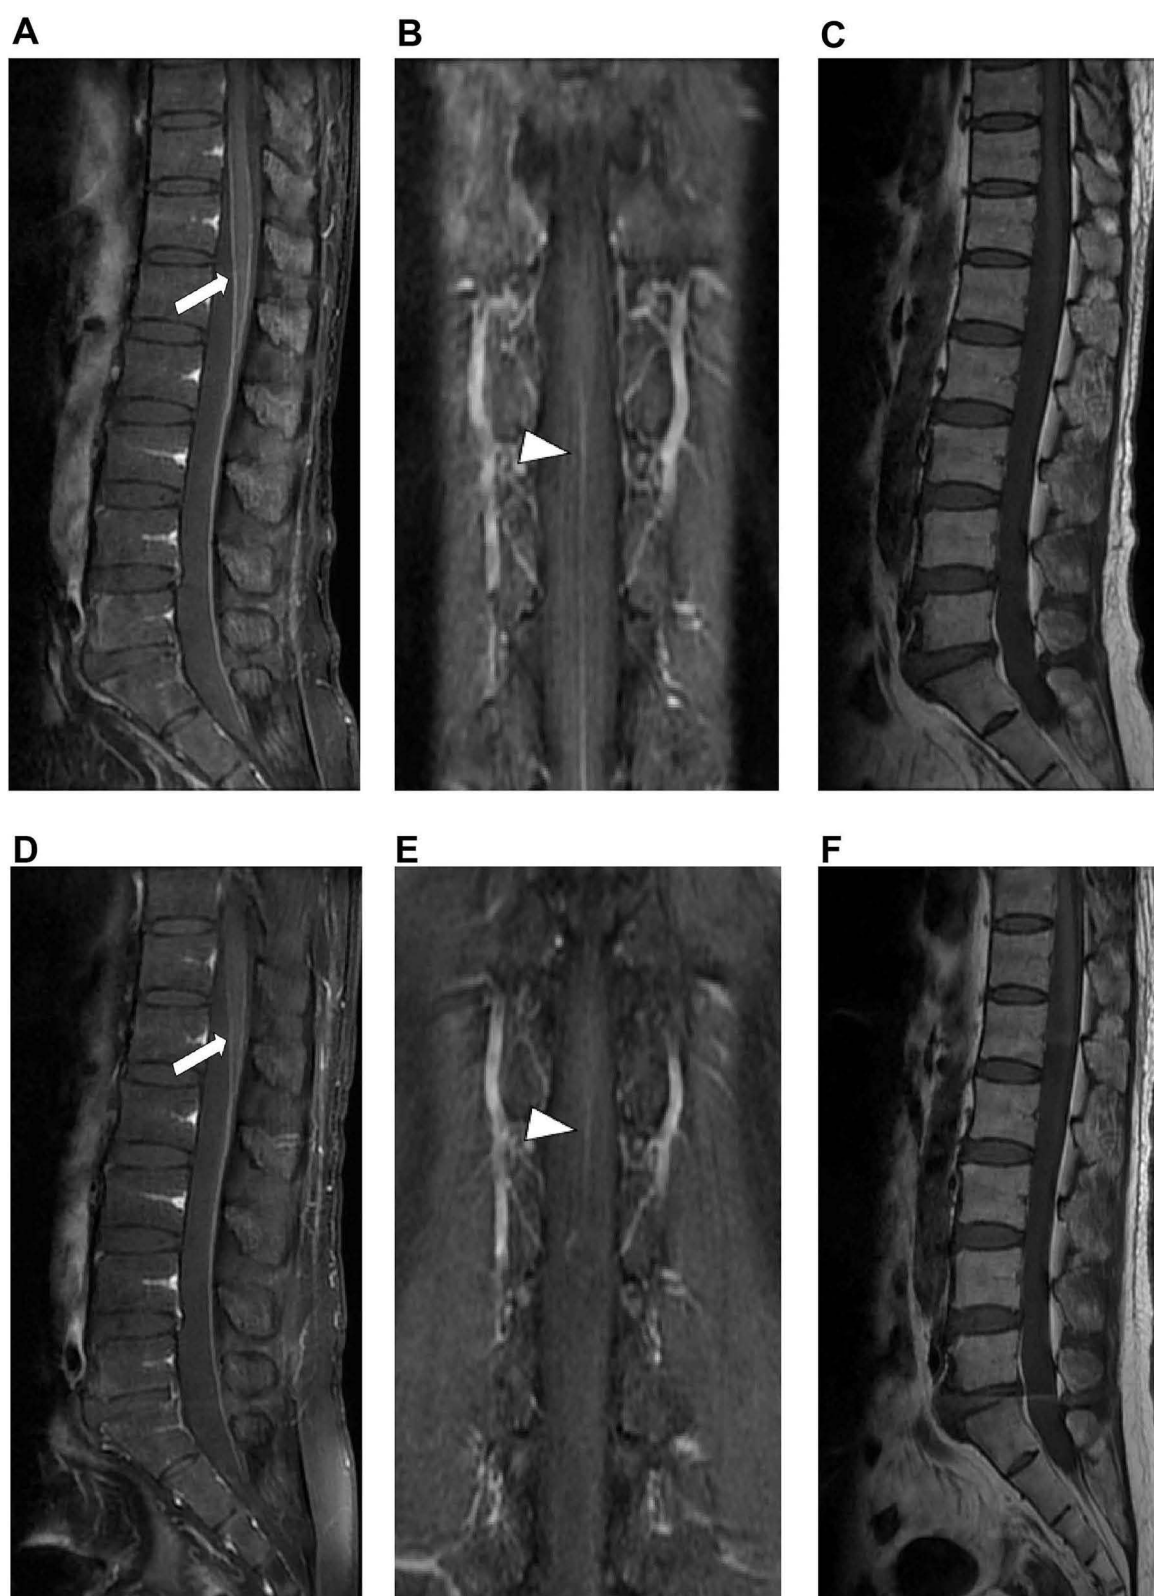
Lumbar spine MRI scan of neurosyphilis patients with LESC showed linear reinforcement in the lumbar region, conus medullaris, and cauda equina. (A, D) Sagittal T1-postgadolinium images reveal leptomeningeal enhancement (arrow). (B, E) Coronal T1-postgadolinium images reveal leptomeningeal enhancement (arrowhead). (C, F) T1-weighted sagittal image. (D–F) One year later, linear enhancement of the lumbar region had been decreased (arrow and arrowhead).
